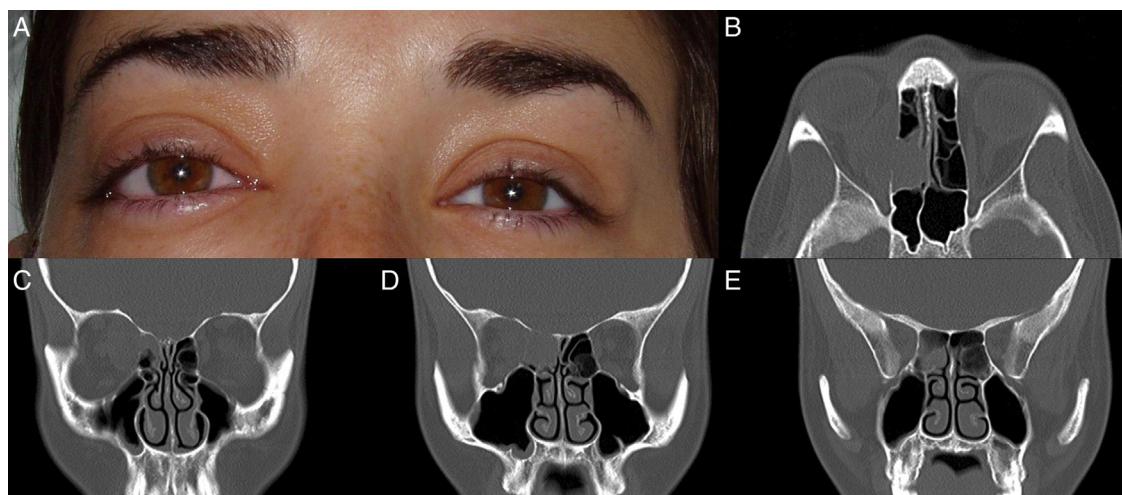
(A) Discrete right eye exophthalmos over the left one. (B-E) CT cross-section (B) and coronal (C-E): partial right side ethmoidal scene is occupation with discontinued bone extension in the lamina papyracea and presence of well defined soft tissue 27 mm x 17 mm isodense image involving orbital fat and orbital vertex.
